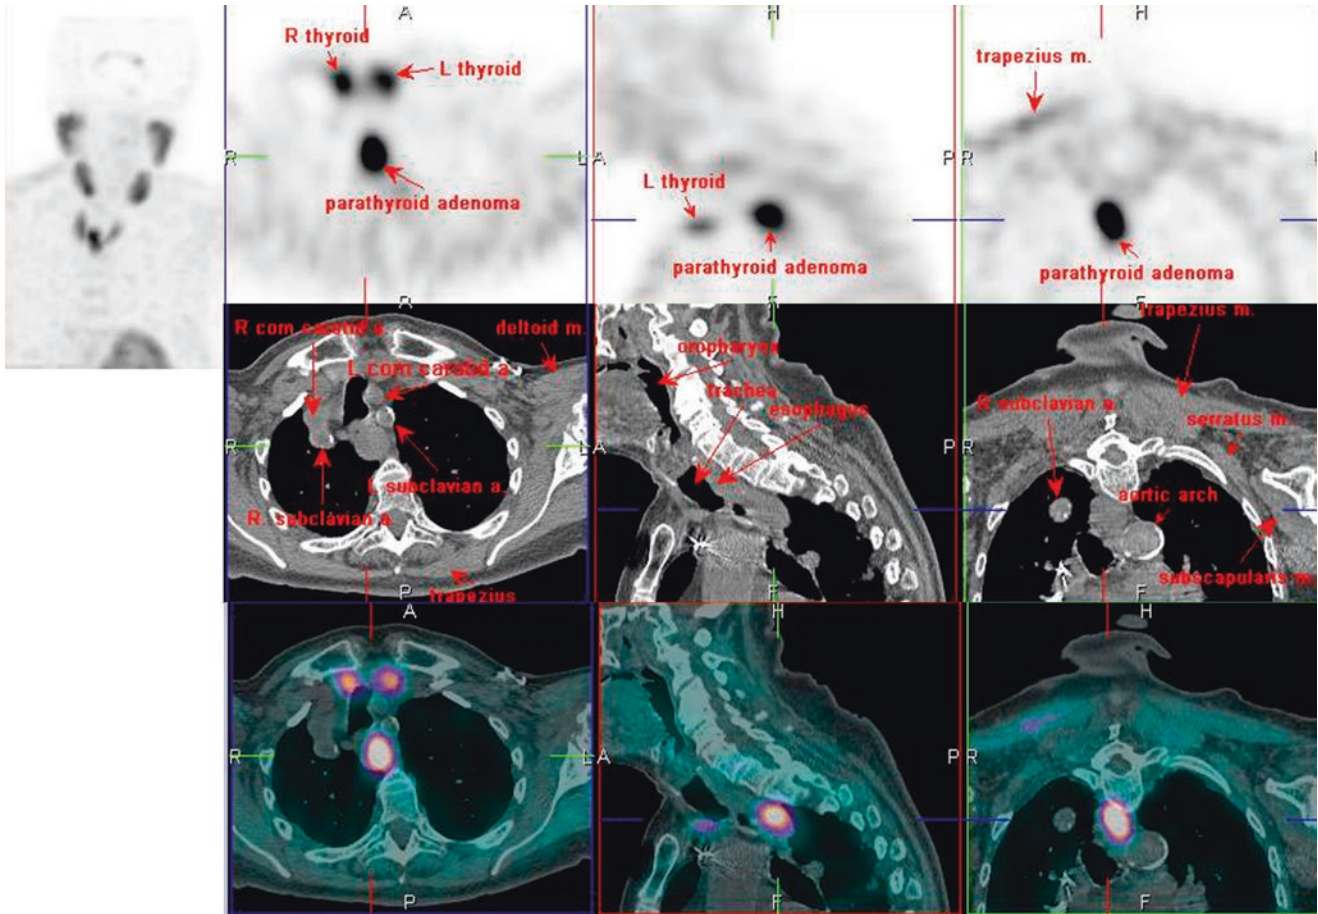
^{99m}Tc -MIBI SPECT/CT
